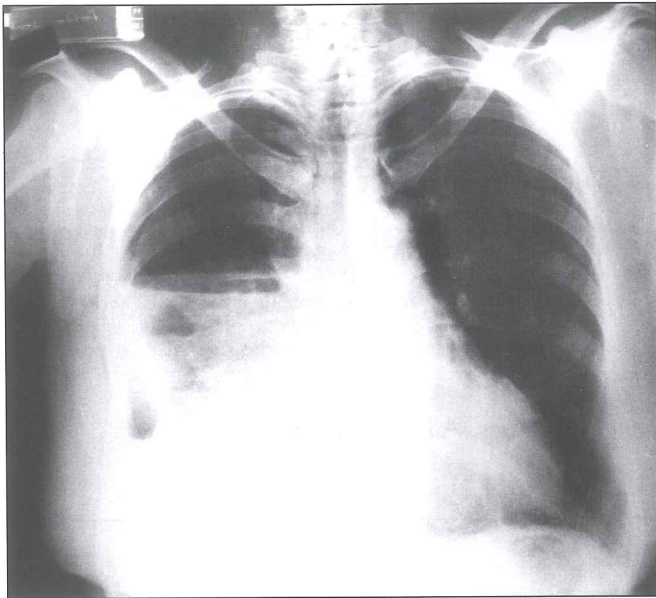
Chest X-ray showing the right hydropneumothorax on presentation.
